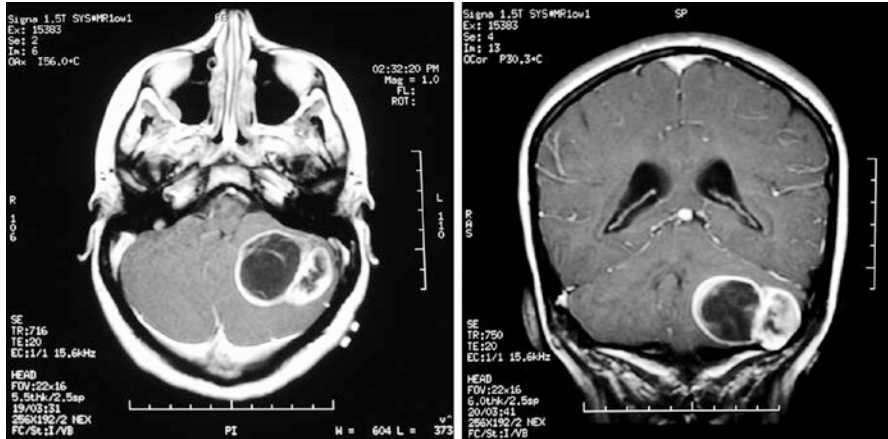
Brain MRI (axial and coronal sections) of a patient with a left cerebellar hemangioblastoma. The contrast-enhancing nodule is lateral and the cyst medial creating left to right mass effect
